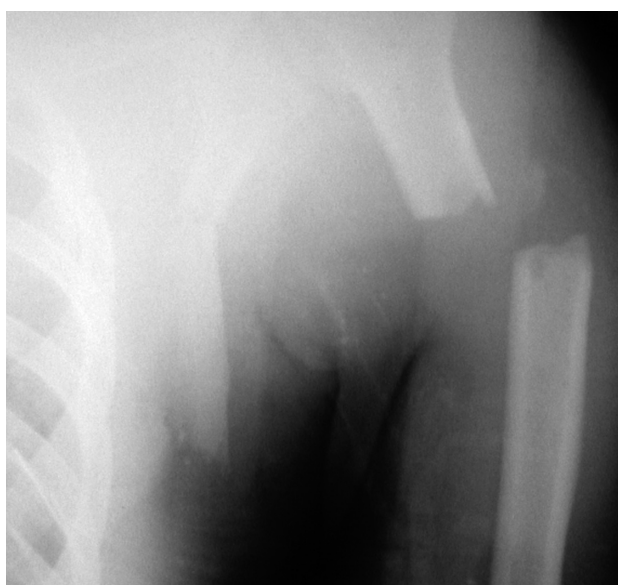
Humerus fracture and scapula fracture are seen in this radiograph.
